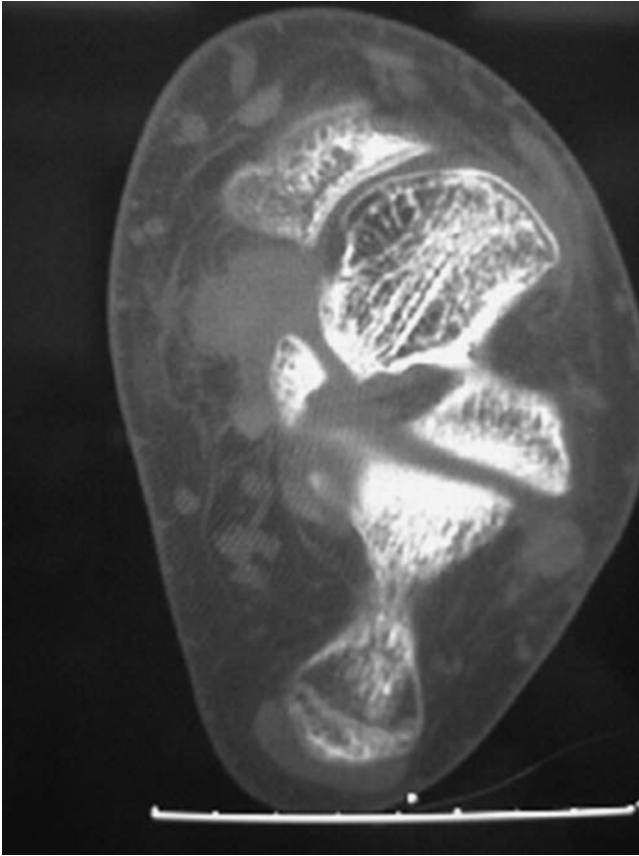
CT scan axial view shows marked talar head uncov-erage (“ball is not in cup”). There is also significant incongruity of the subtalar joint. (Courtesy of Dr. Thomas Lee, MD.)
